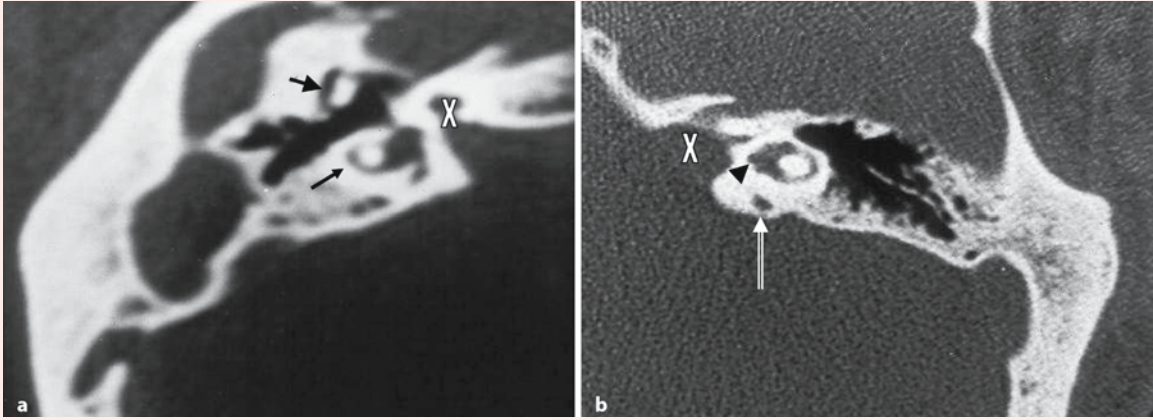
Branchio-oto-renal syndrome: CT scans, showing a widened internal acoustic canal (crosses) and hypoplastic cochlea (arrowheads) in patients A (a) right ear) and B (b) left ear)
